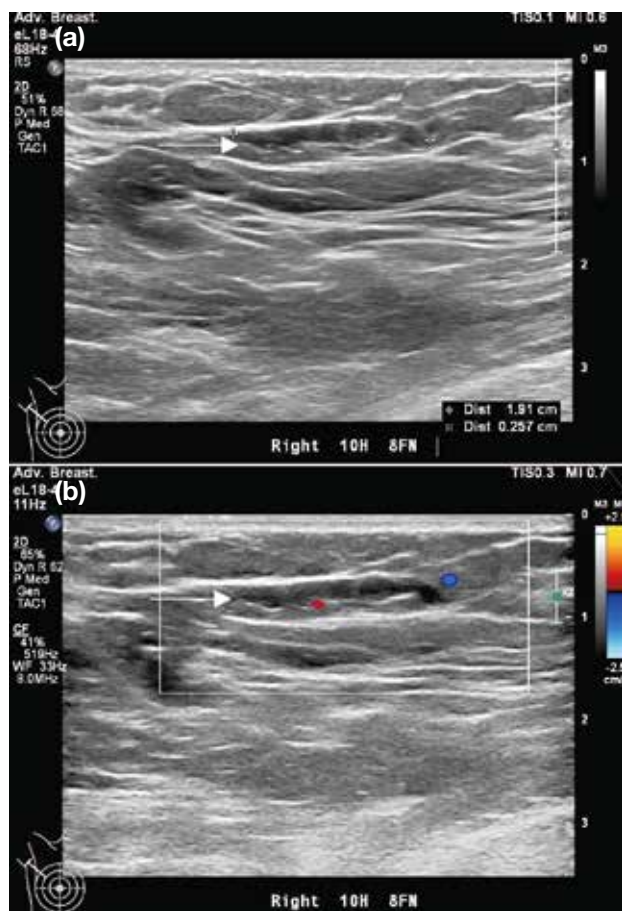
Mondor's disease. Ultrasound of the right breast. At the 10 o'clock position near the axilla, (a) an elongated tubular lesion with a beaded appearance is visualised (arrow). (b) No Doppler signal is detected within the structure (arrow).
